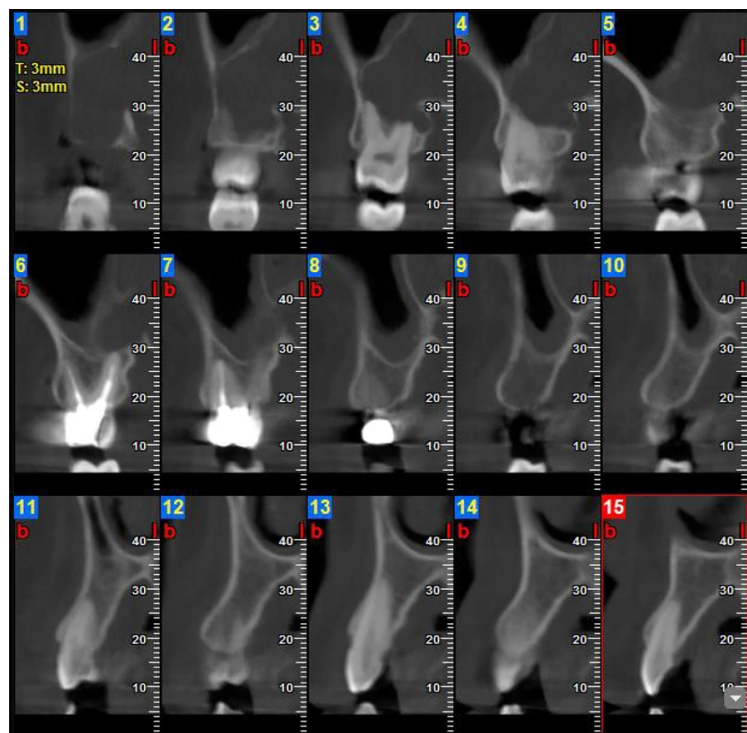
Selected CBCT cross-sectional images showing root resorption of the maxillary second molar adjacent to the lesion.
